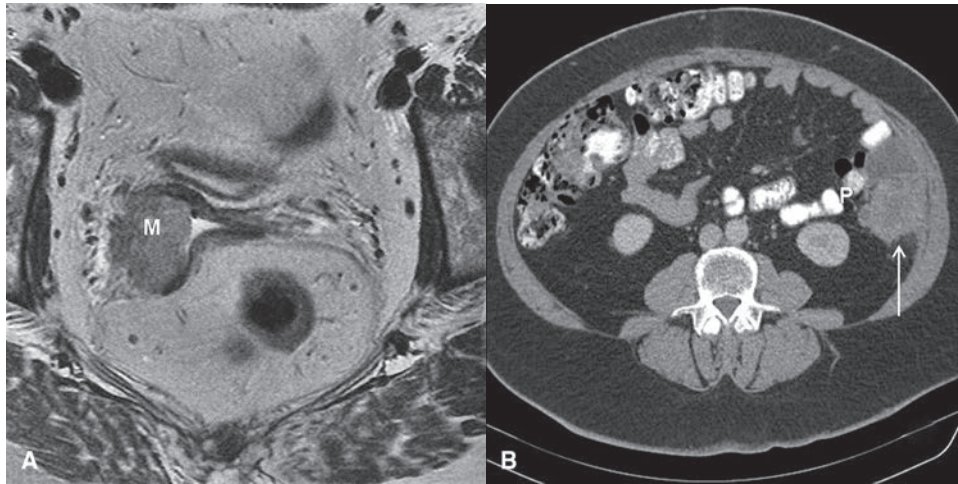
Recurrent endometrial carcinoma. Axial T2W FSE MR image (A) shows a mass of intermediate signal intensity in the vaginal vault on the right (M in A) in keeping with tumor recurrence from a serous papillary carcinoma of the endometrium. CT image (B) of the same patient shows a peritoneal deposit (arrow in B) in the right paracolic gutter.
